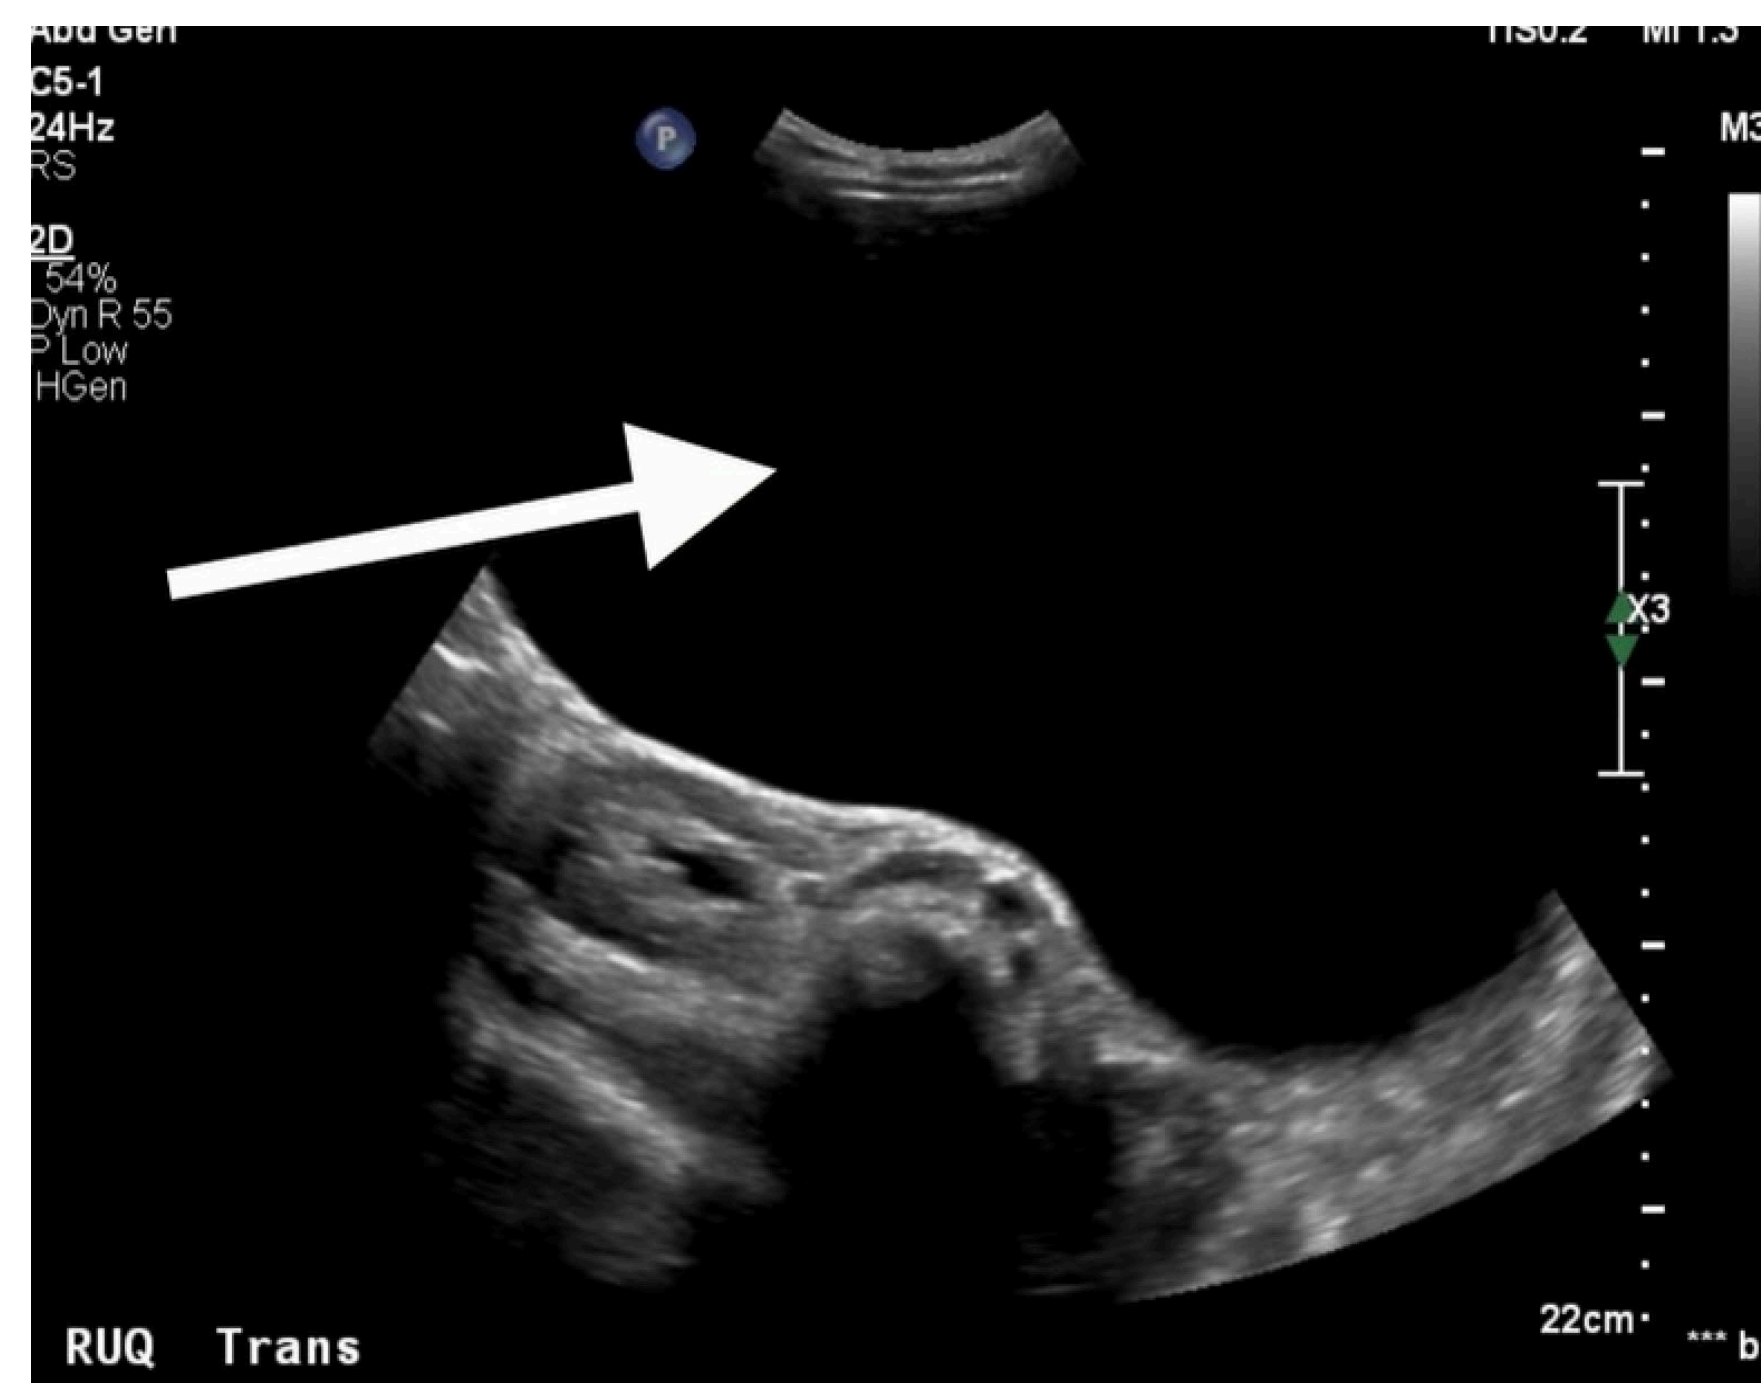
Abdominal Ultrasound
